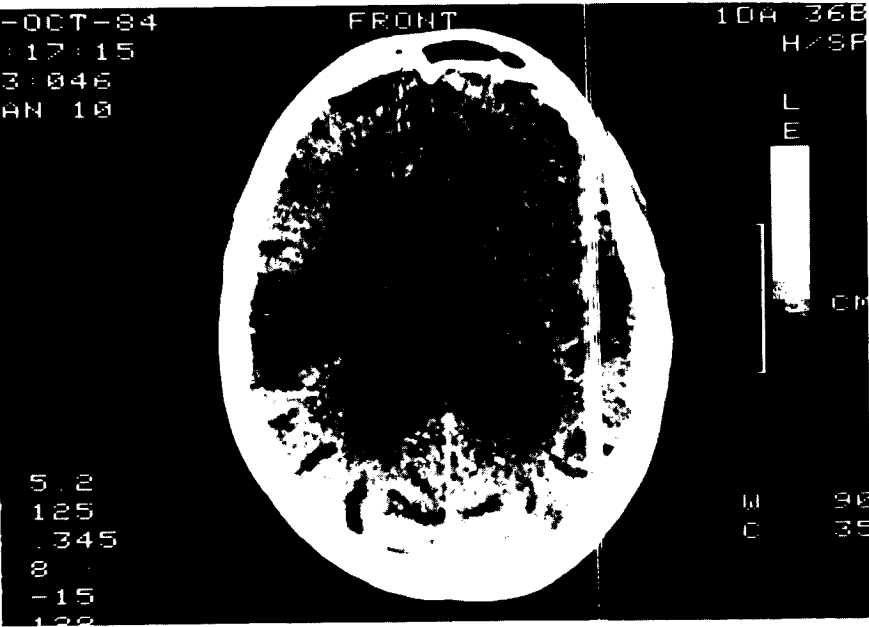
CT scan (Case 2) demonstrating recent right parietal infarction.
